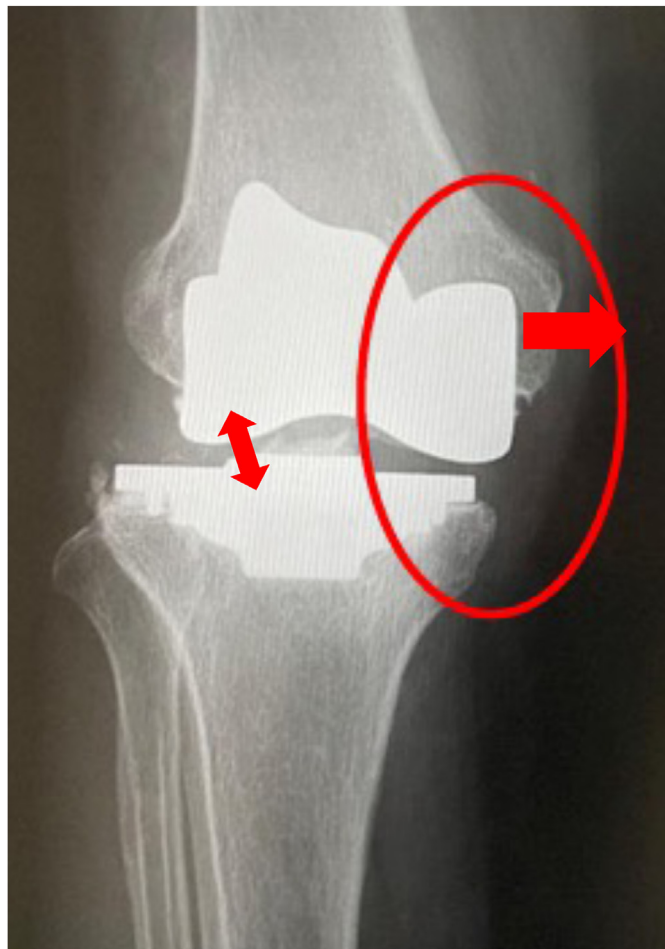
Plain radiographs (antero-posterior view) at 8 months after surgery. Medial migration of the femur and the collision of the lateral articular surface of the femoral component with the UHMWPE locking mechanism of the tibial component (red arrow and circle).
